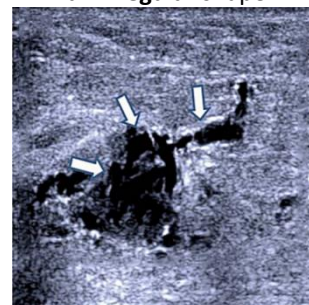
Ultrasound features of breast cancer "structural distortion" in breast cancer (arrows)
